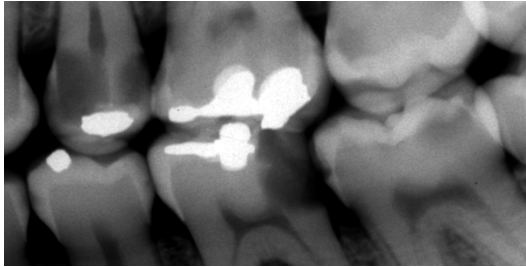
Bite-wing radiograph of left side tooth crowns demonstrates multiple locations with deep caries.
